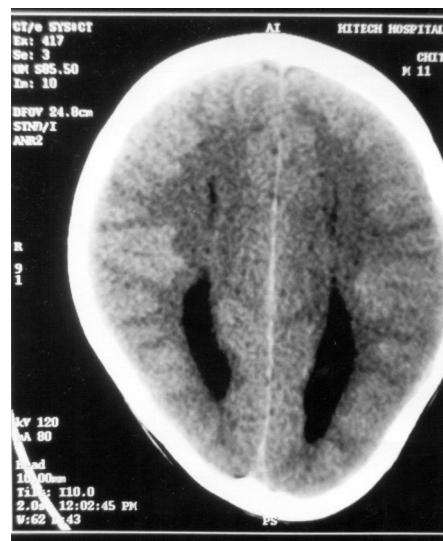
CT brain : Parallel temporal horns.
